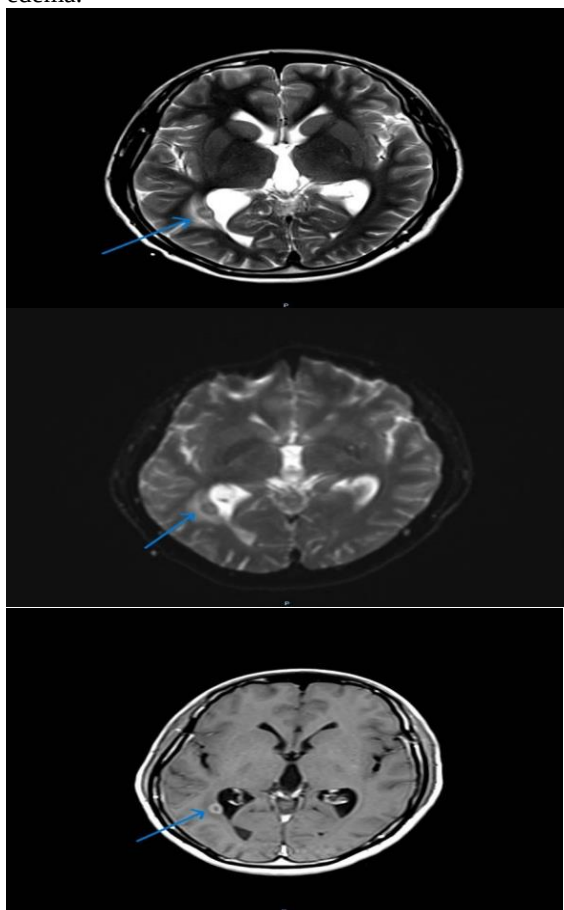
MRI brain showing a right occipital lobe abscess. (A) T2-weighted image demonstrates a hyperintense lesion with surrounding edema. (B) Diffusion-weighted image reveals restricted diffusion within the cavity. (C) Post-contrast T1-weighted
